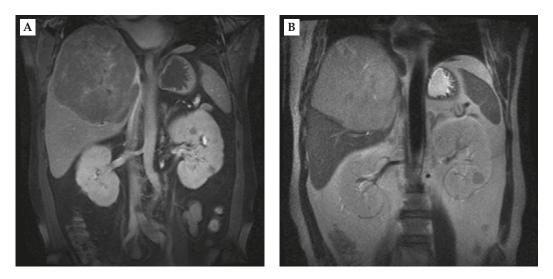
Magnetic resonance imaging showed a well-defined mass with (A) hypointensity on T1-weighted imaging, and (B) hyperintensity on T2-weighted imaging.
